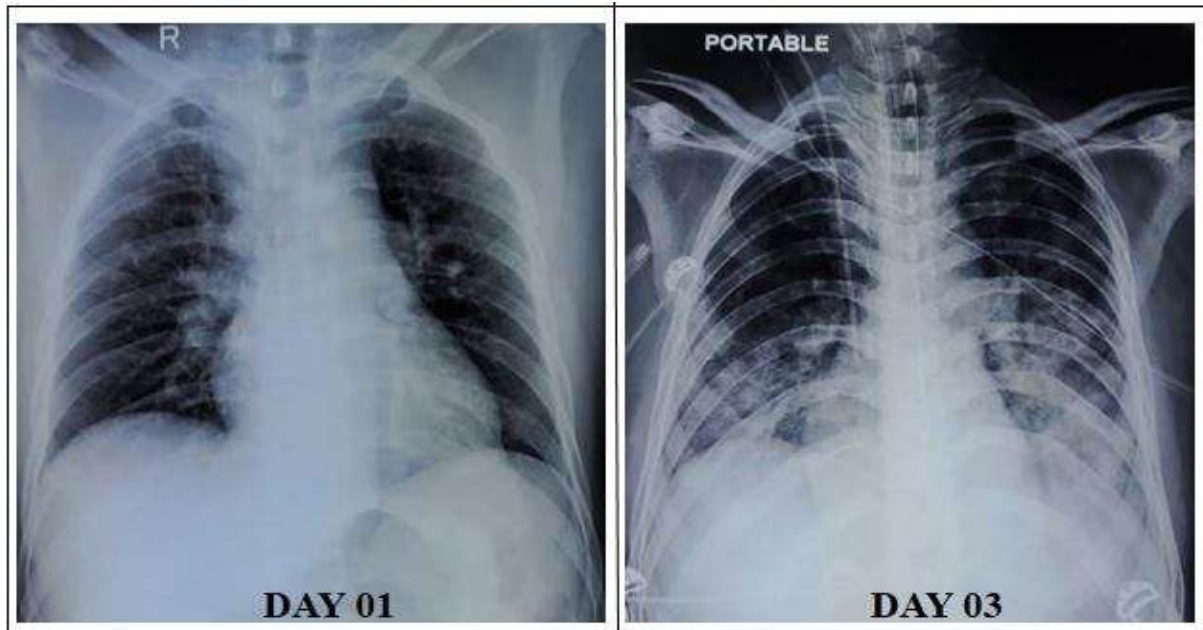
Chest radiograph on the day of admission shows both lung fields are clear. Chest radiograph on the 3th day of admission shows showed diffuse bilateral coalescent opacities involving lower lung fields.
